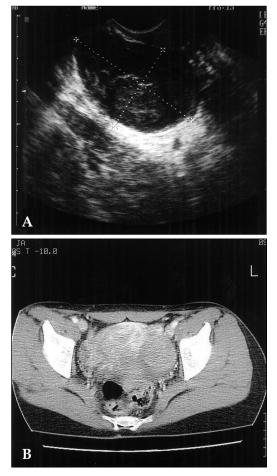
Transvaginal ultrasonography of a homogenousechoic mass originated in the left ovary (A), and abdominal and pelvic computed tomography (CT) scans of a left ovarian solid mass which was well-demarcated, round, homogenous and well-enhanced. No pathologic findings of other pelvic organs, ascites, and lymphatic enlargements were detected (B).
